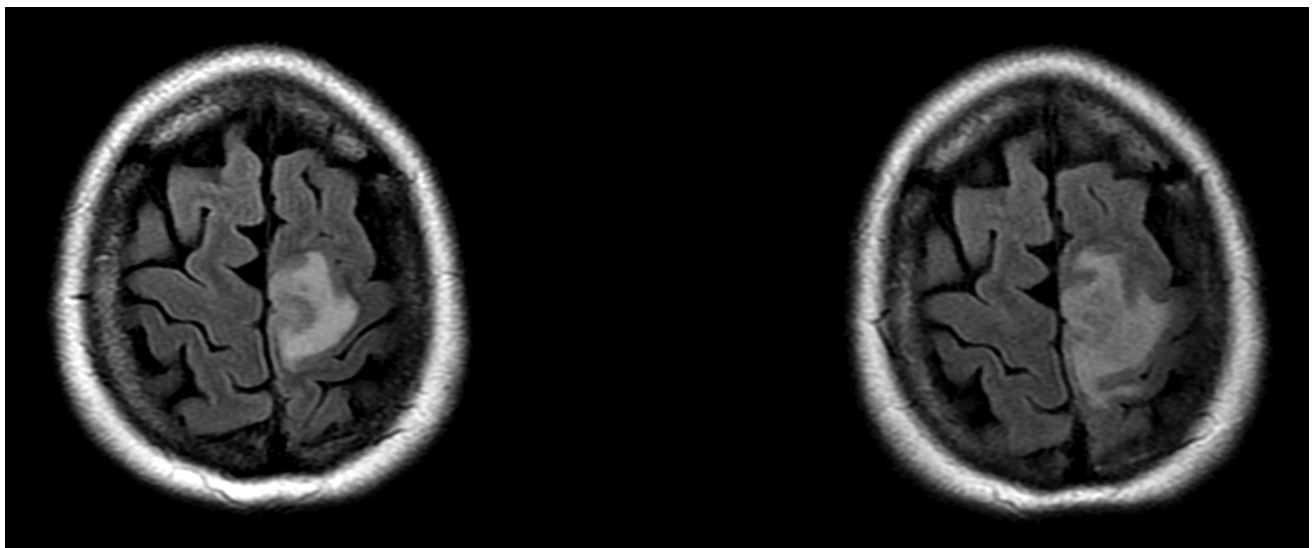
MRI brain at similar level on day 2 (left) and 9 (right) post admission. Early abscess/cerebritis of the left medial frontal lobe is apparent.
